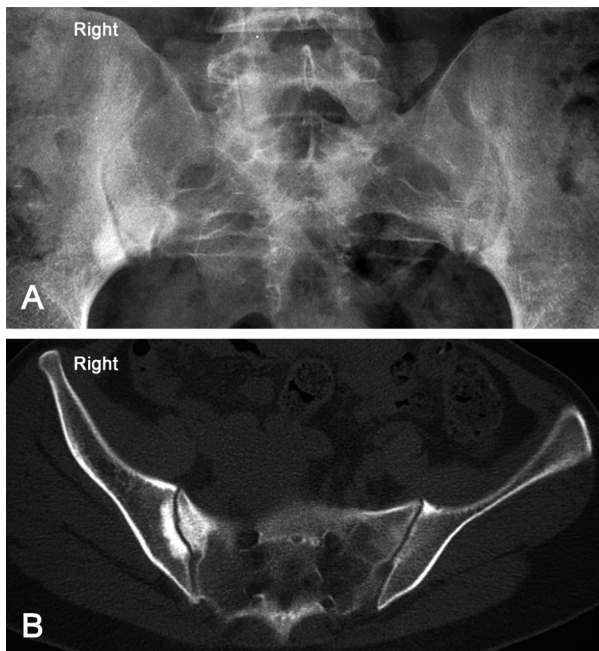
Plain radiography (A) and computed tomography scan (B) of both sacroiliac joints taken 16 days after symptom onset. Radiographic survey of the pelvis revealed sclerosis of both iliac bony plates. Both the plain radiography and computed tomography scan showed no blurring or erosion of the joint margins, and the joint spaces were normal.
